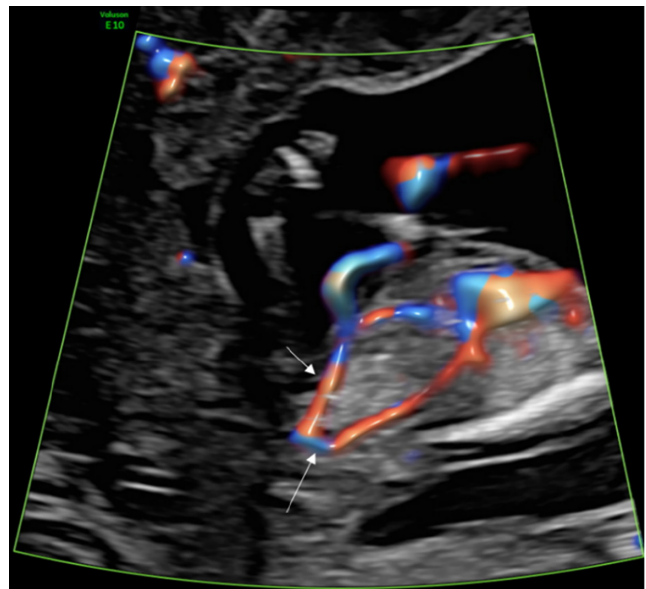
Color Doppler imaging of the fetus showing an umbilical artery (small arrow) emanating from the iliac artery (large arrow).
